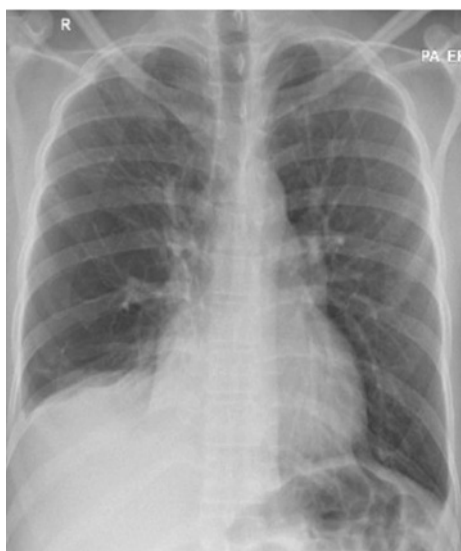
Chest X-ray (posteroanterior view) showing mild blunting of the right costophrenic angle. Subsequent chest ultrasound revealed a moderate right-sided pleural effusion that was predominantly posterior and loculated, indicating that plain radiography significantly underestimated effusion size.
